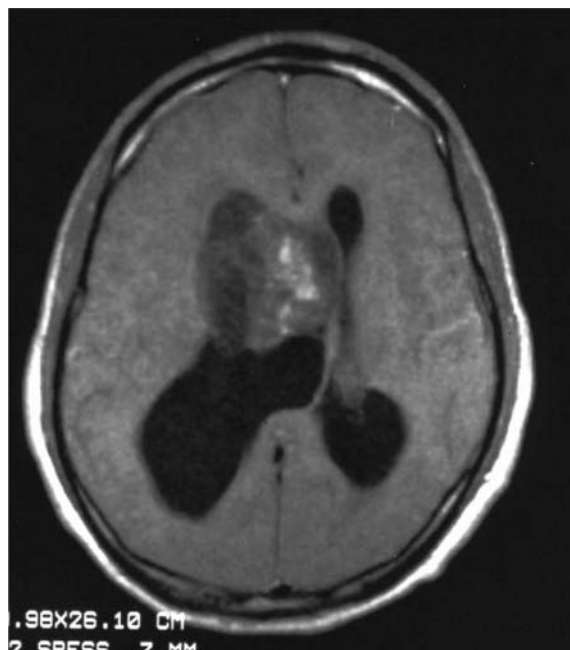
Sub-ependymoma, MRI, T1. From the Neuroradiology Unit, Dpt Neuroscience, University of Turin
